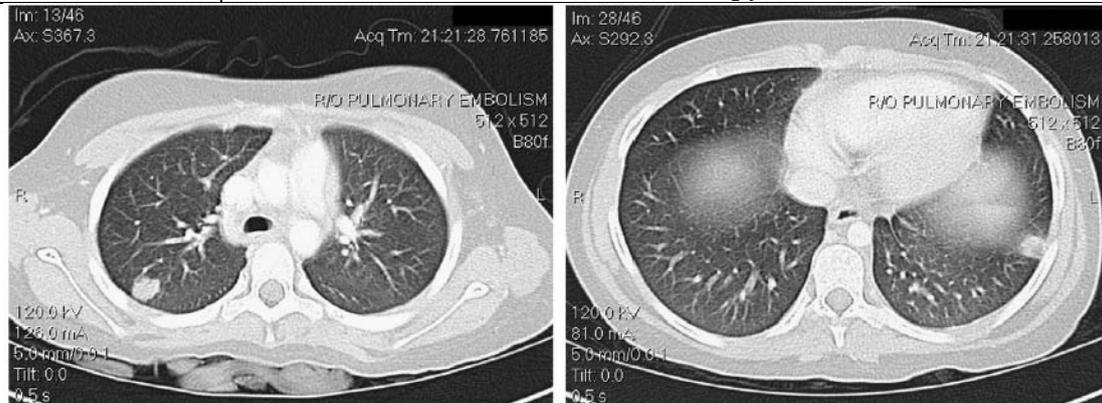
Series: Axial CT images of the chest with contrast showing opacification of bilateral mastoid processes, bilateral enlarged cervical lymph nodes, and multiple pulmonary nodules.
